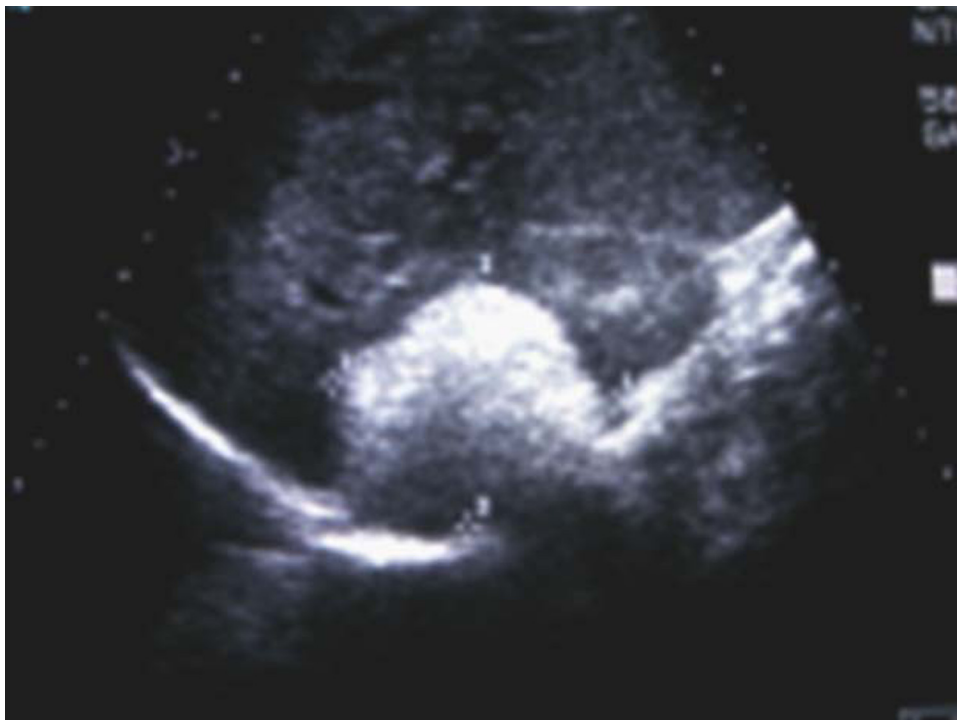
Large uniformly hyperechoic mass of the upper pole of the right kidney with sharp borders where echogenicity of the mass is at least equal to that of renal sinus fat. A picture of the classic ultrasonography appearance of acute myeloid leukaemia.
